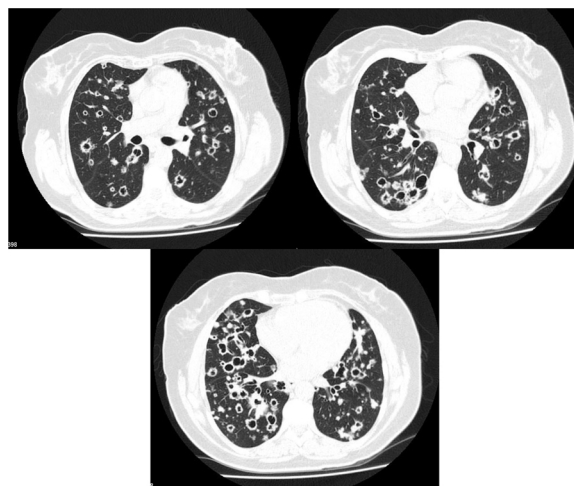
Thoracic CT scan of a 62 year-old woman with stage IV lung adenocarcinoma, showing multiple bilateral thin-walled air-filled cavities with a diffuse distribution.
